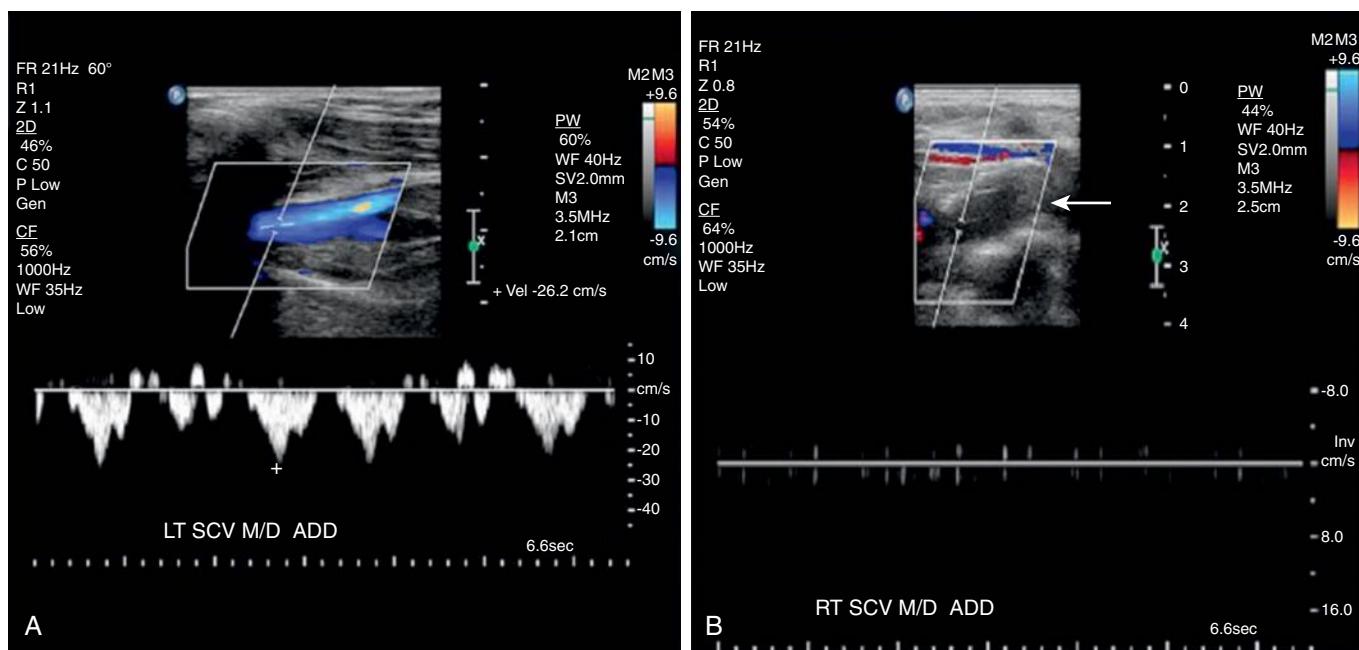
Duplex Ultrasound Images of the Axillosubclavian Vein. (A) Demonstrates a normal axillosubclavian vein. (B) Demonstrates a thrombosed axillosubclavian vein, as demonstrated by lack of both color flow and venous waveform, with the presence of an acute thrombus (see arrow).
